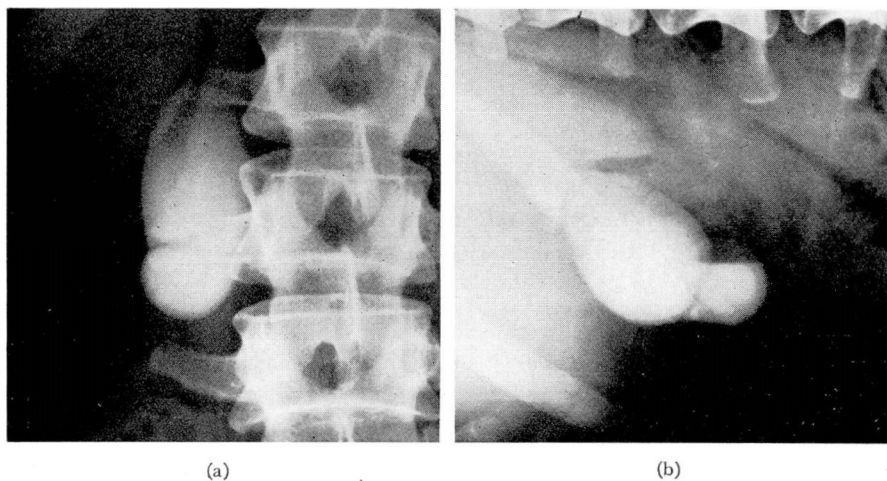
Normal gallbladder. (a) Posteroanterior prone roentgenogram showing normal gallbladder. (b) Posteroanterior lateral decubitus roentgenogram where a layer of bile with low specific gravity and only slight dye-density is trapped in the top of a Phrygian cap.
